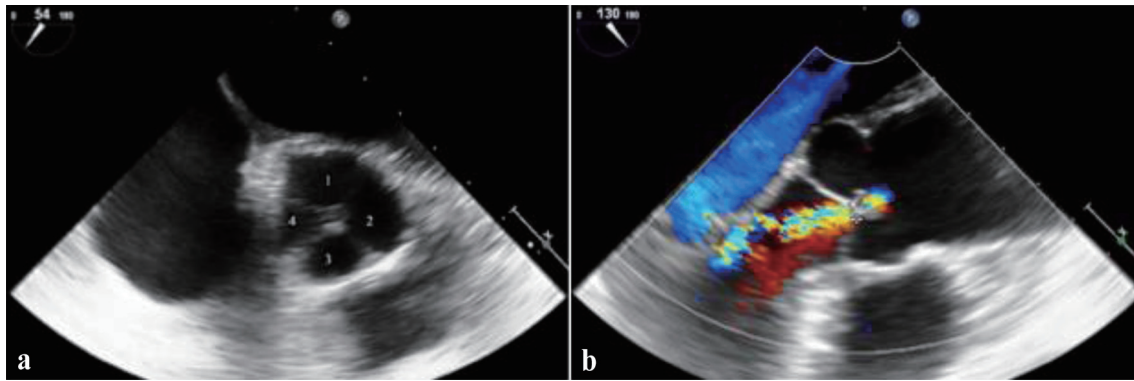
Transesophageal echocardiography views of the aortic valve. (a) Mid-esophageal short-axis view at 54°, demonstrating a quadricuspid aortic valve (Hurwitz and Roberts type C) with four distinct cusps. The individual cusps are labeled to aid visualization. (b) Mid-esophageal long-axis view at 130° with color Doppler, showing central aortic regurgitation jet consistent with moderate aortic insufficiency.
